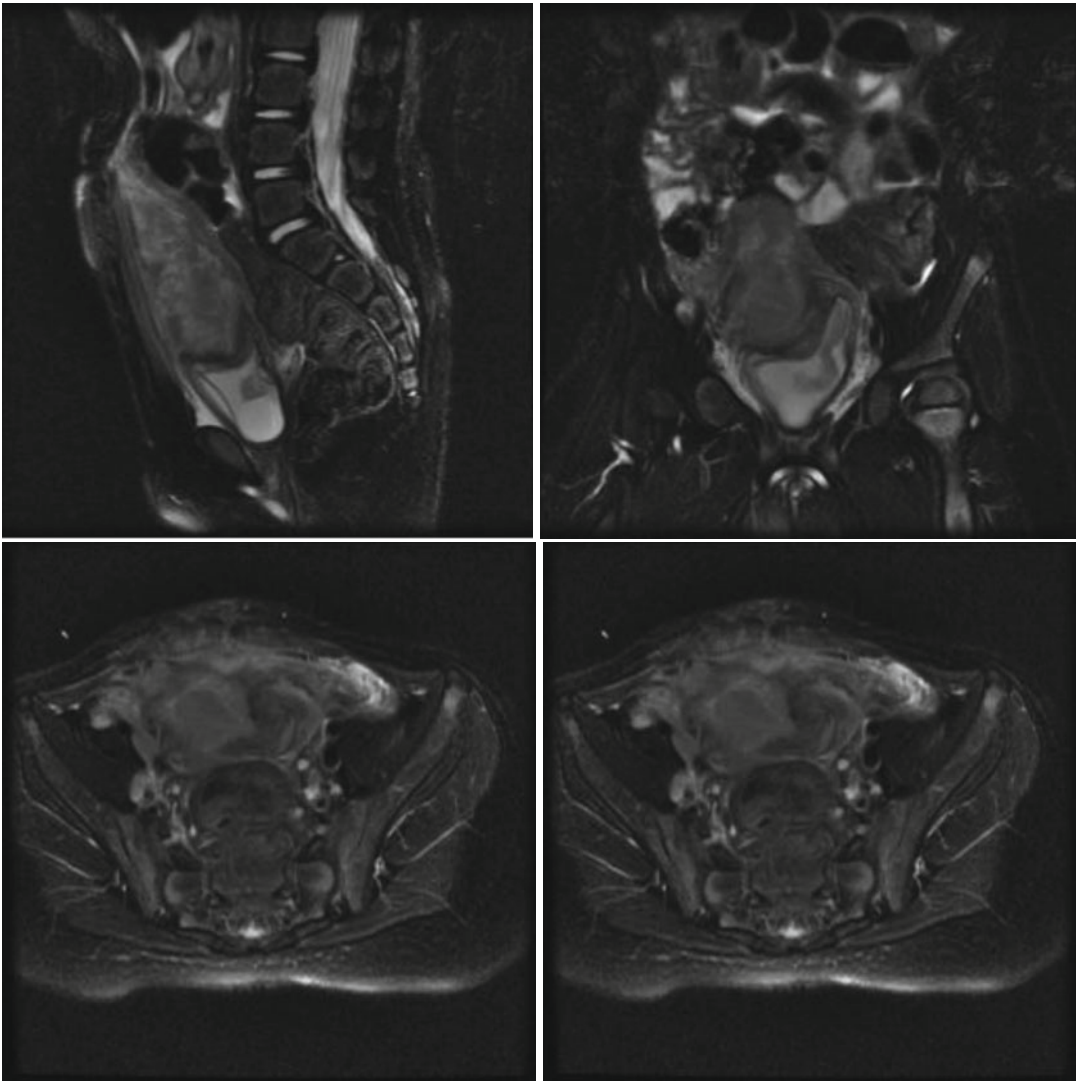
MRI shows an expansive formation, with ovular morphology, behind the anterior abdominal wall, in the median-paramedian. The collection appears pluri-concamerate, with walls hypointense on
